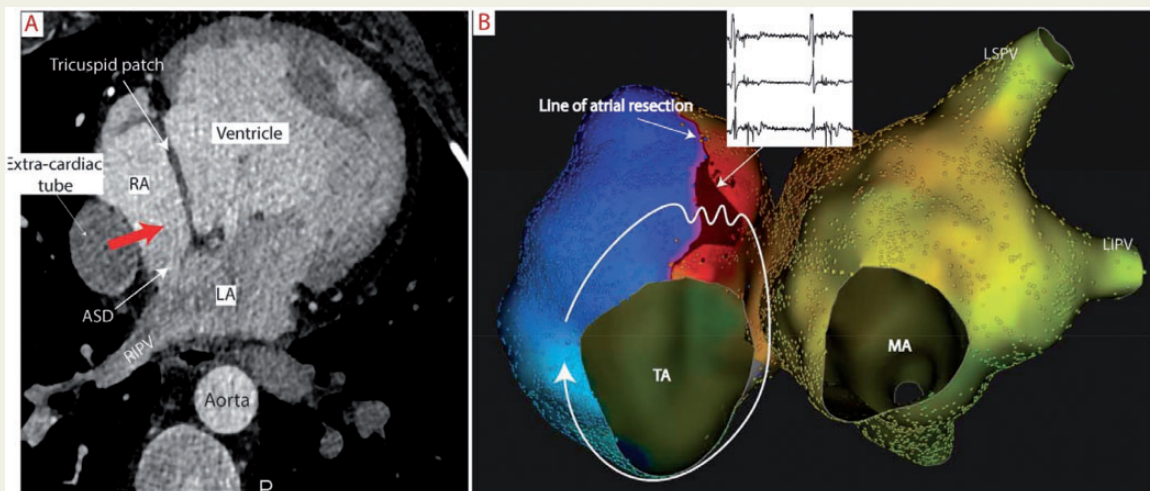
(A) Computed tomography shows the apposition of the tube and right atrial wall, which predicts a safe trans-conduit puncture (red arrow). (B) LAO view of the right and left atria showing a peri-tricuspid macroreentrant tachycardia. The tachycardia uses a gap with a slow conduction on an anterior line of block. ASD, atrial septal defect; LA, left atrium; LAO, left anterior oblique; LIPV, left inferior pulmonary vein; MA, mitral annulus; RA, right atrium; RIPV, right inferior pulmonary vein; TA, tricuspid annulus.
